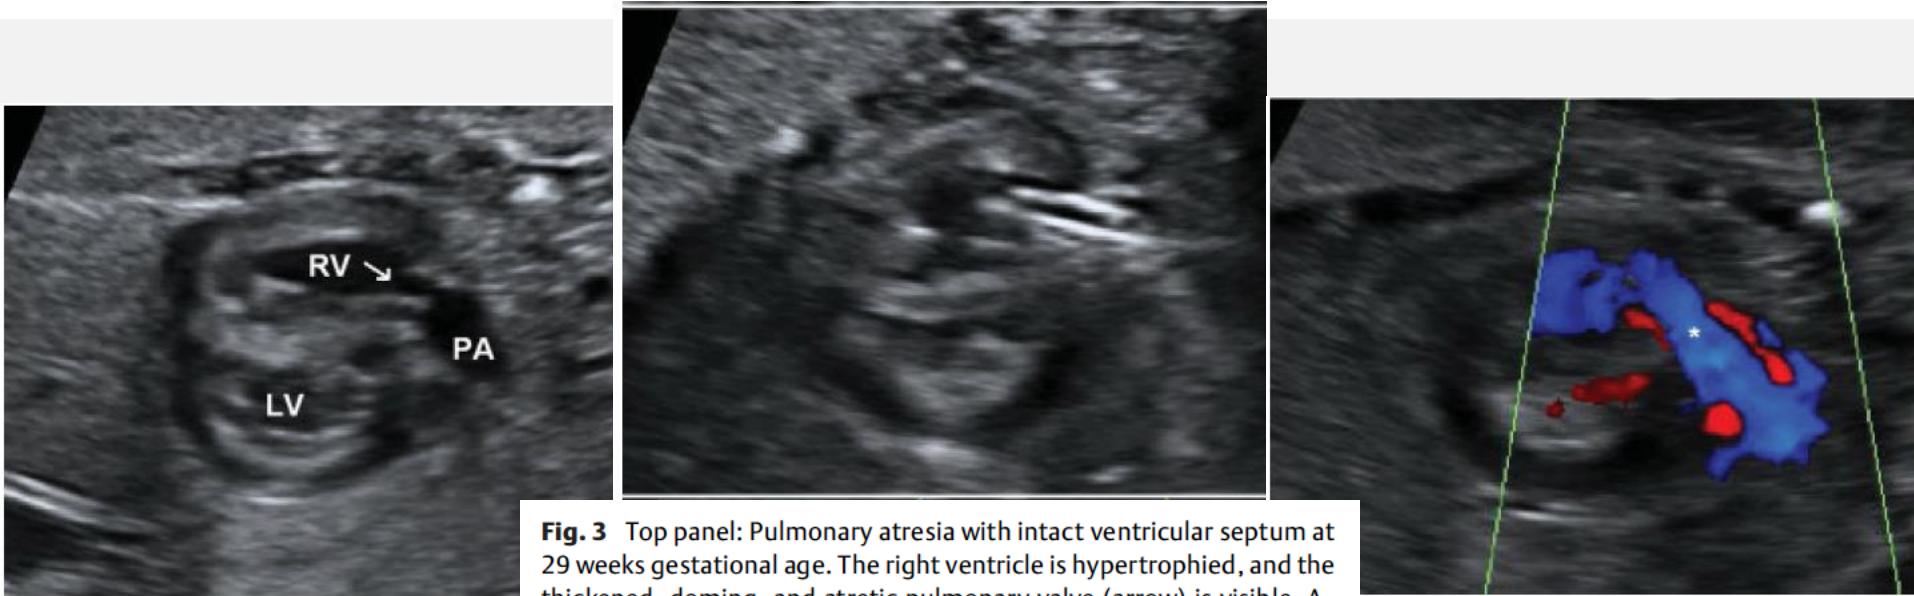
Top panel: Pulmonary atresia with intact ventricular septum at 29 weeks gestational age. The right ventricle is hypertrophied, and the thickened, doming, and atretic pulmonary valve (arrow) is visible. A normally sized right pulmonary artery is visualized. Middle panel: After perforation of the pulmonary valve with a cannula, an angioplasty balloon is inflated in the right ventricular outflow tract and across the pulmonary valve. Bottom panel: Still-frame color Doppler image after pulmonary valve perforation and balloon angioplasty in the same patient. There is a broad jet of anterograde flow (asterisk) into the pulmonary artery. LV, left ventricle; RV, right ventricle; PA, main pulmonary artery.
